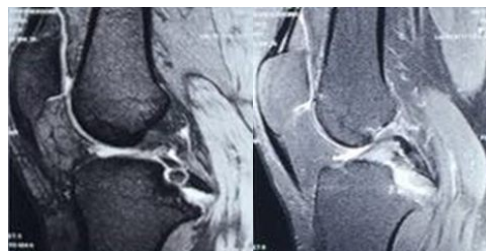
2 Preoperative Knee MRI images showing intact PCL substance and avulsed fragment of PCL
